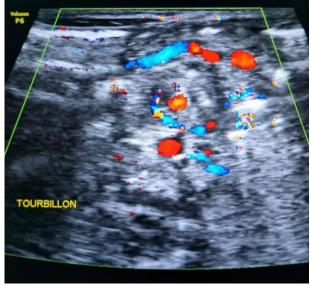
Doppler ultrasound showing the 'whirlpool sign,' with inversion of the positioning of the mesenteric vessels
